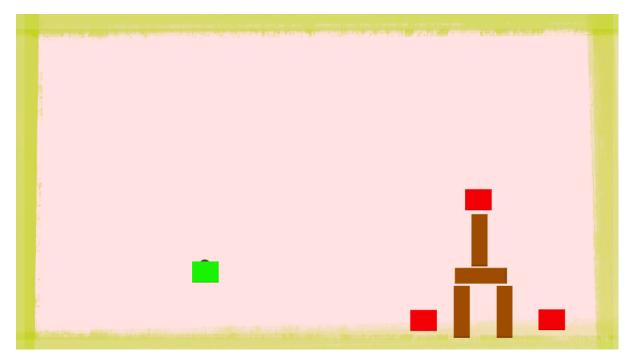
Test from the X-Ray mini-game.
